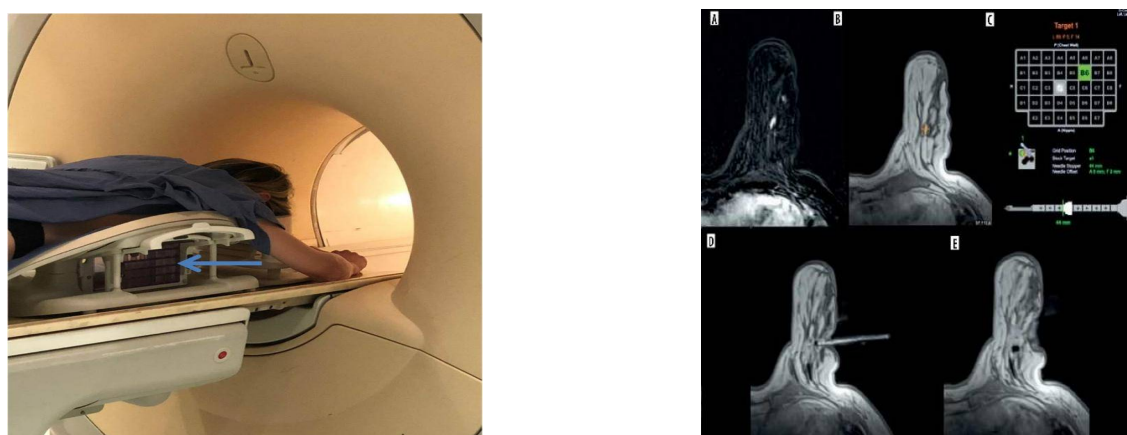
(d). MRI-Guided Breast Biopsy
